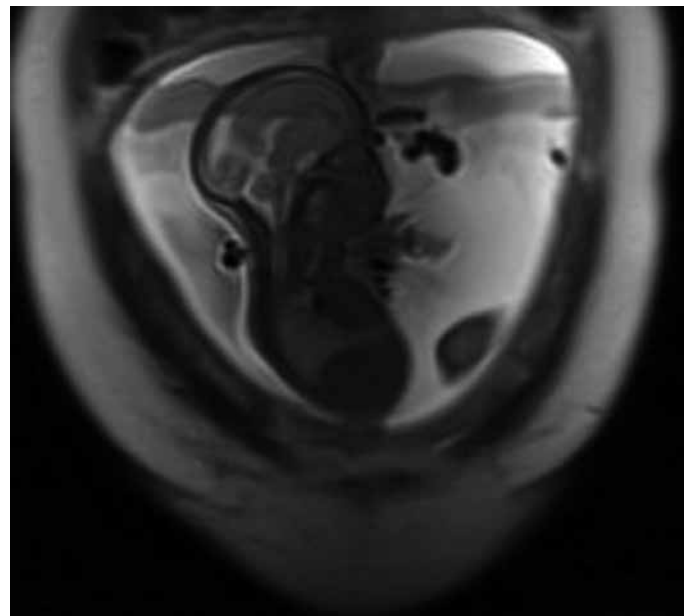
Fetal magnetic resonance imaging demonstrated slight shrinkage of the goiter after the treatment
